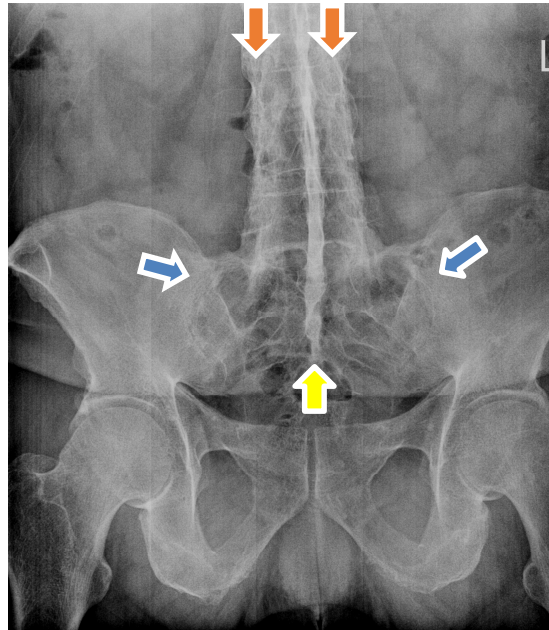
Anteroposterior lumbopelvic radiograph demonstrating ossification of the zygapophyseal (facet) capsules (railroad track sign, orange arrows), ossification of the supraspinous and interspinous ligaments (dagger sign, yellow arrow), and calcification of the bilateral sacroiliac ligaments with partial ankylosis of the sacroiliac joints (blue arrows).
